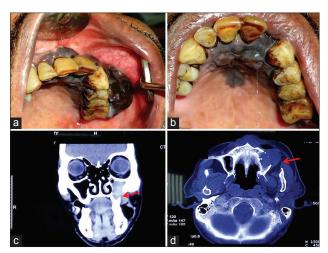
(a and b) Brownish black, irregular growth extending from 13 to 27 on both buccal and lingual aspects involving ridge area. Contrast enhanced computed tomography showing (c) a homogeneous mass with the erosion of left alveolar arch and (d) extension into the left lateral margin of hard palate
